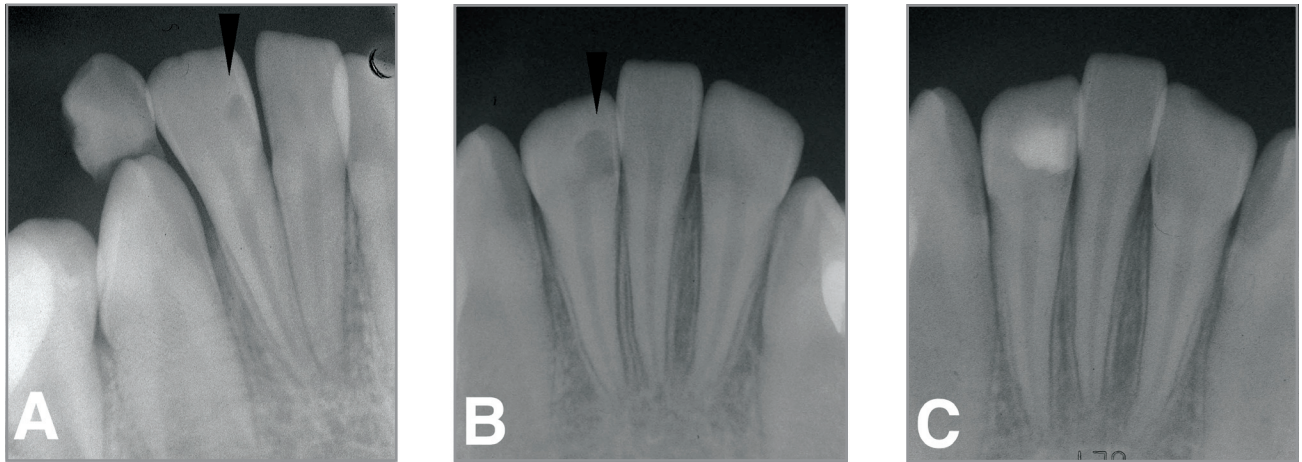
(a) Periapical radiograph of the permanent mandibular right lateral incisor at age 11 years 4 months. Progression of the lesion was not apparent compared to Figure 2b (arrow). (b) Periapical radiograph at age 12 years showing the extended lesion (arrow). (c) Periapical radiograph at 18 months after treatment (age 13 years 8 months) showing apical maturation.
